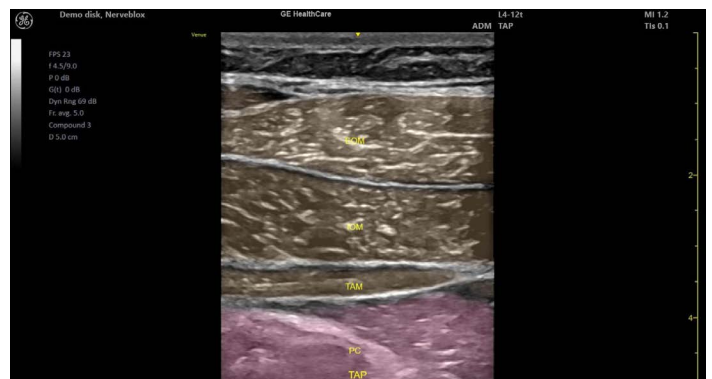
Ultrasound image of transversus abdominal plane (TAP) nerve block.
